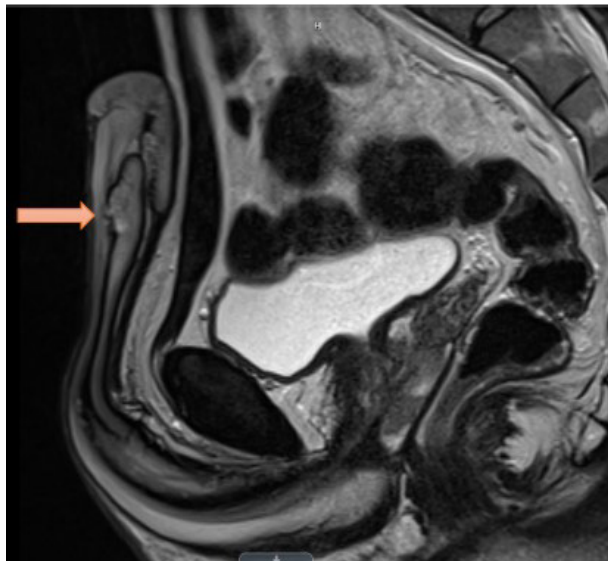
MRI image demonstrating a capsular defect at the ventral aspect of the left corpora cavernosum.
